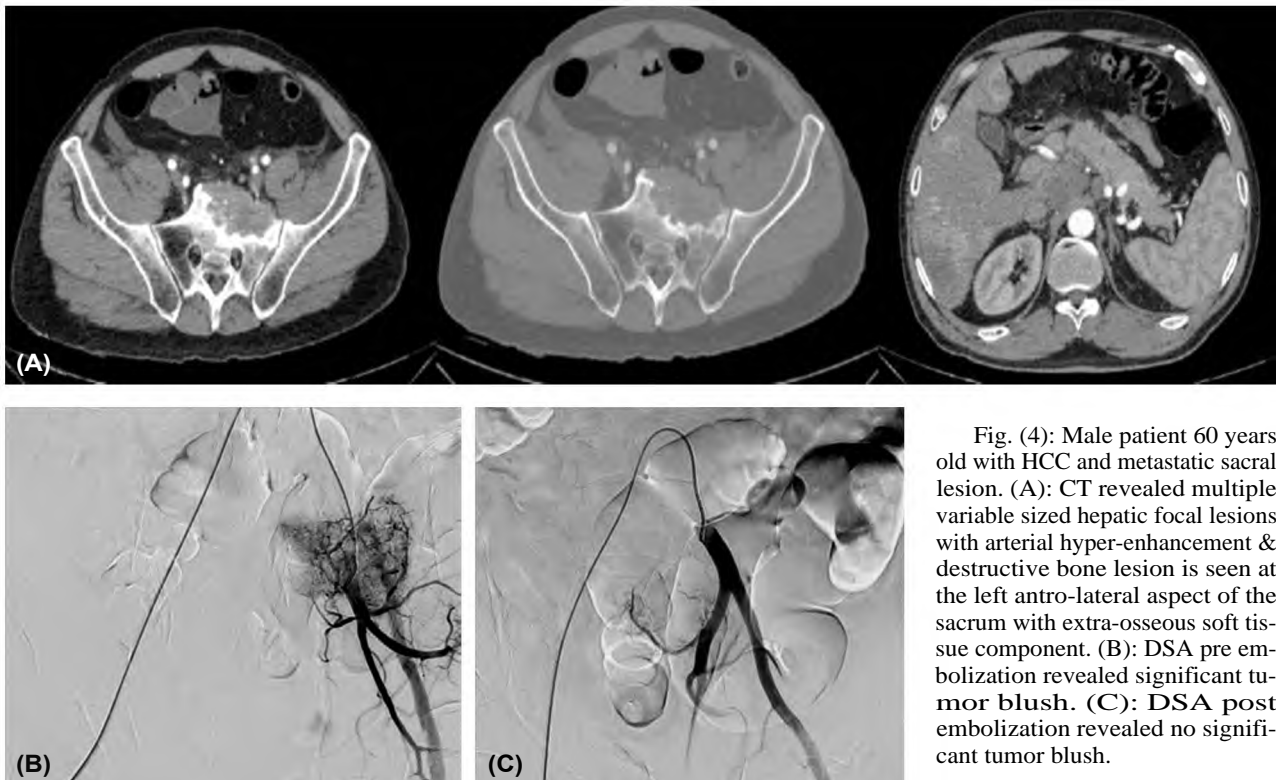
Male patient 60 years old with HCC and metastatic sacral lesion. (A): CT revealed multiple variable sized hepatic focal lesions with arterial hyper-enhancement & destructive bone lesion is seen at the left antro-lateral aspect of the sacrum with extra-osseous soft tissue component. (B): DSA pre embolization revealed significant tumor blush. (C): DSA post embolization revealed no significant tumor blush.
